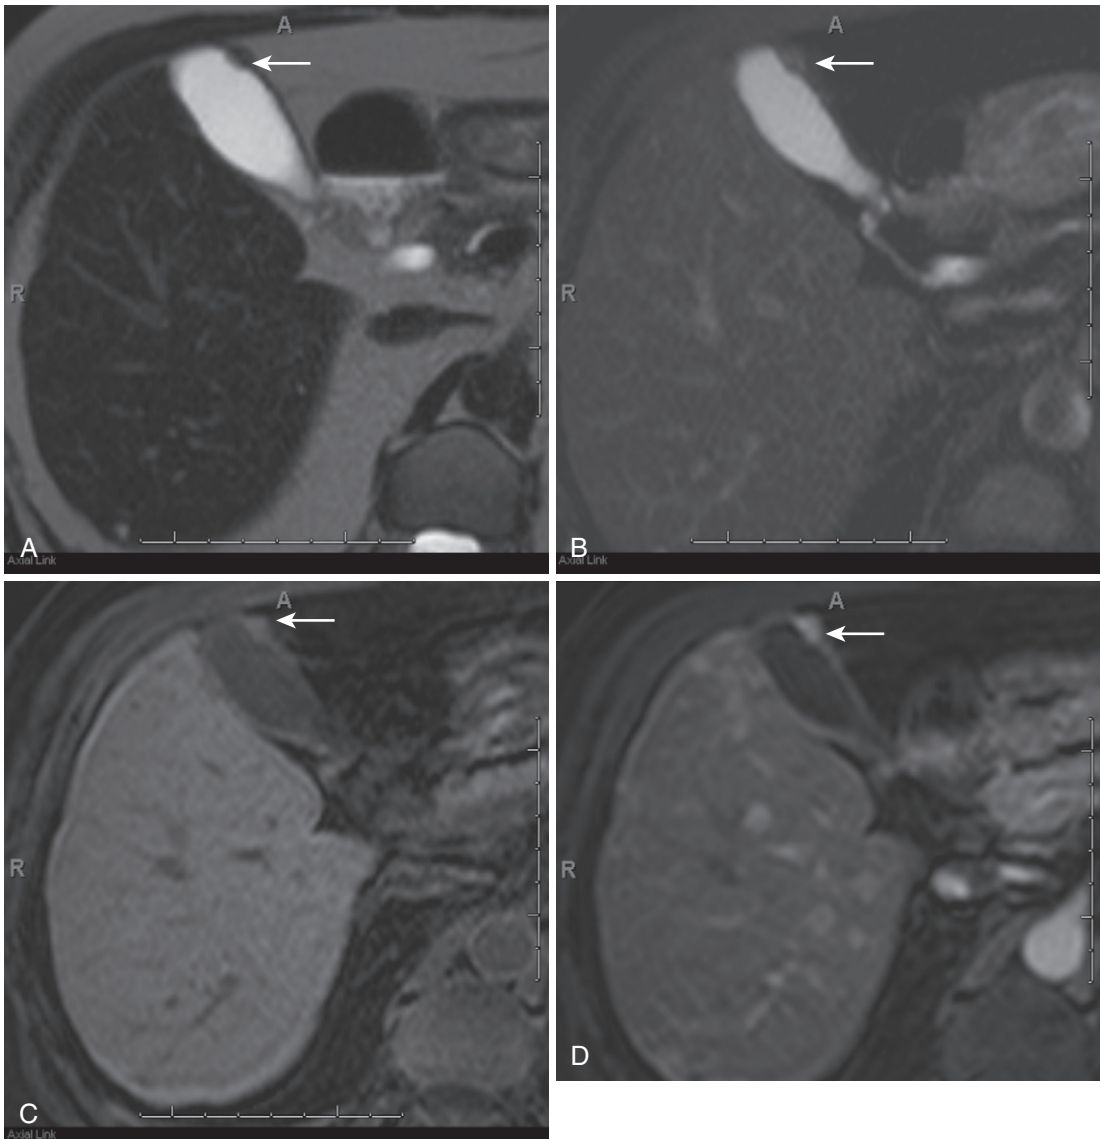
Gallbladder metastasis. T2-weighted (A), fat-suppressed T2-weighted (B), precontrast fat-suppressed T1-weighted (C), and postcontrast fat-suppressed T1-weighted gradient recalled-echo (D) images demonstrate an enhancing mural nodule (*arrow*), in keeping with a metastasis to the gallbladder wall.
